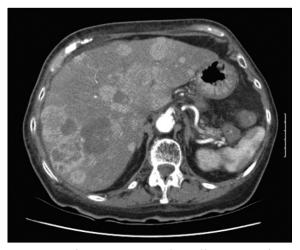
CT scan of a patient presenting with several liver metastases from adenocarcinoma of unknown origin
